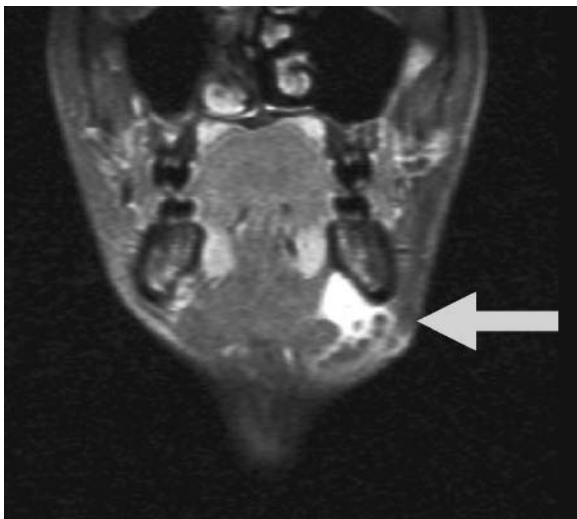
Coronal T2-weighted MRI of plunging ranula
